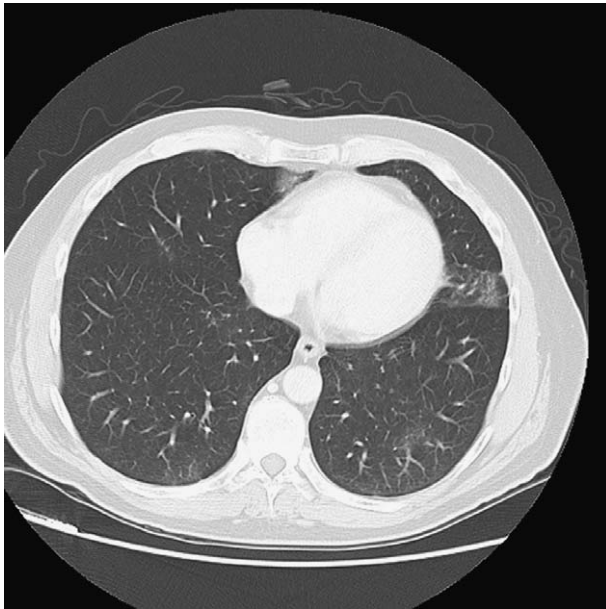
Thorax CT with GGO/DID pattern.
